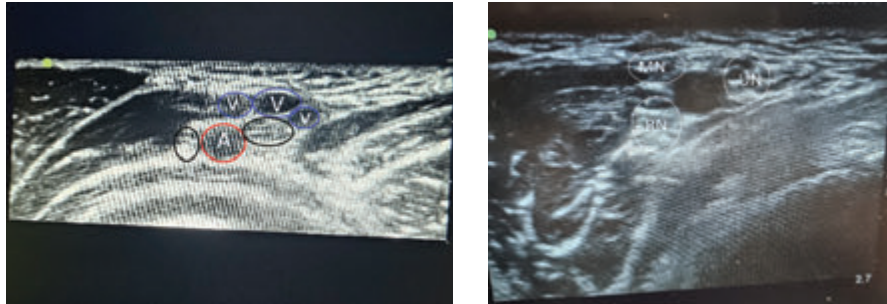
Ultrasound findings of axillary block: A- axillary artery, V – veins, MN – medial nerve, UN – ulnar nerve, RN – radial nerve. The first image is of a 7-year-old patient where the ulnar and median nerves are located medially from the artery and the radial nerve is lateral to the artery. The second image is of a 15-year-old child with a different position of the nerves compared to the previous one.
